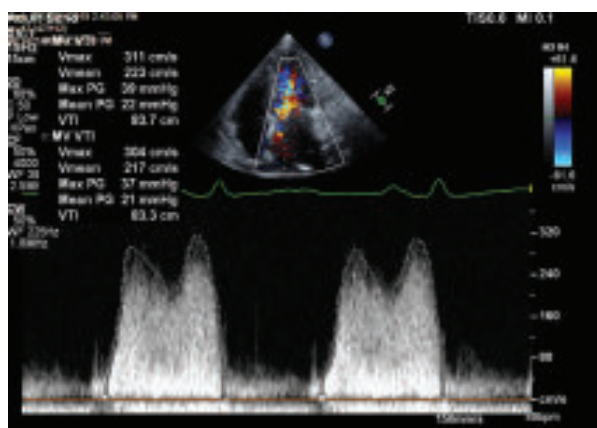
Echocardiographic feature consistent with mitral valve obstruction by LA mass*
